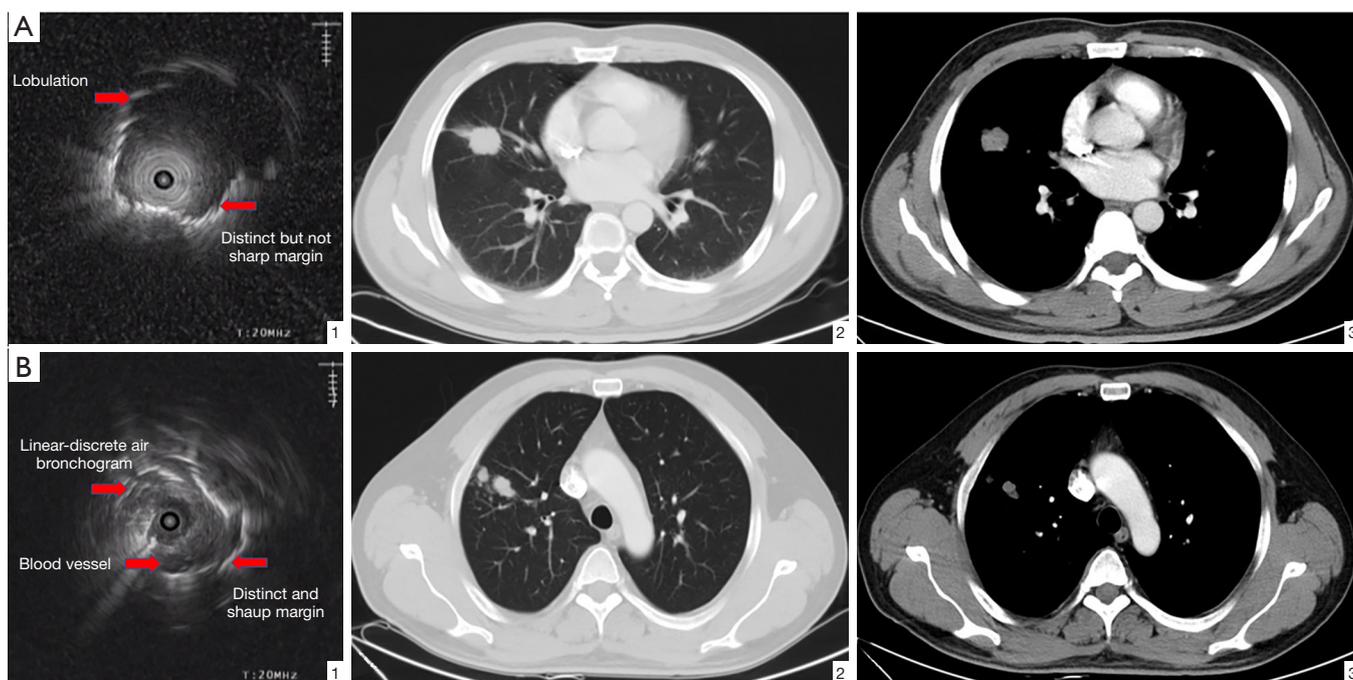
Representative cases of benign and malignant. (A1) Representative case of malignant lesion in radial endobronchial ultrasonographic features: lobulation, distinct but not sharp margin, absence of linear-discrete air bronchogram, absence of blood vessel. The sum score was 4. (A2,A3) Corresponding chest CT images of the malignant lesion. (B1) Representative case of benign lesion in radial endobronchial ultrasonographic features: irregular, distinct and sharp margin, linear-discrete air bronchogram, blood vessel. The sum score was 0. (B2,B3) Corresponding chest CT images of the benign lesion.
